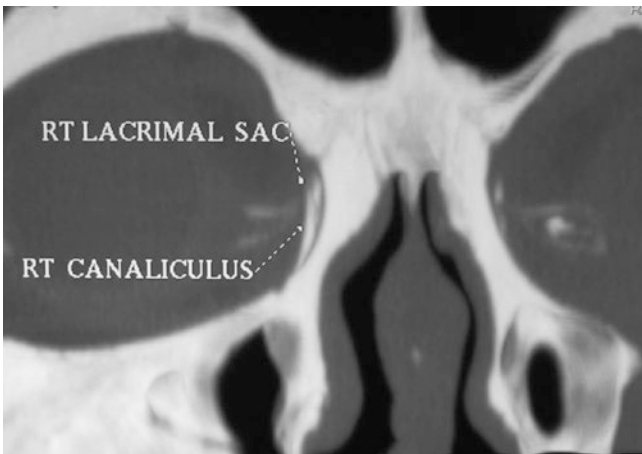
CT-DCG, coronal image showing the dye within the canaliculi and lacrimal sac
